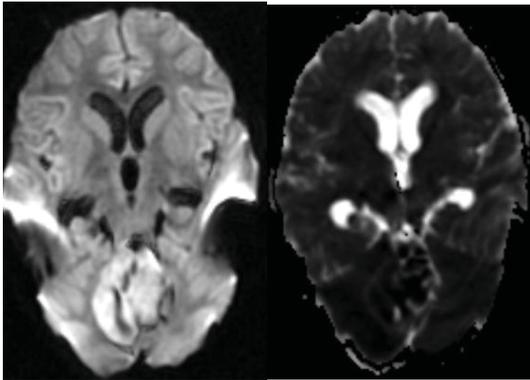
The mass demonstrates restricted diffusion on DWI sequences.
